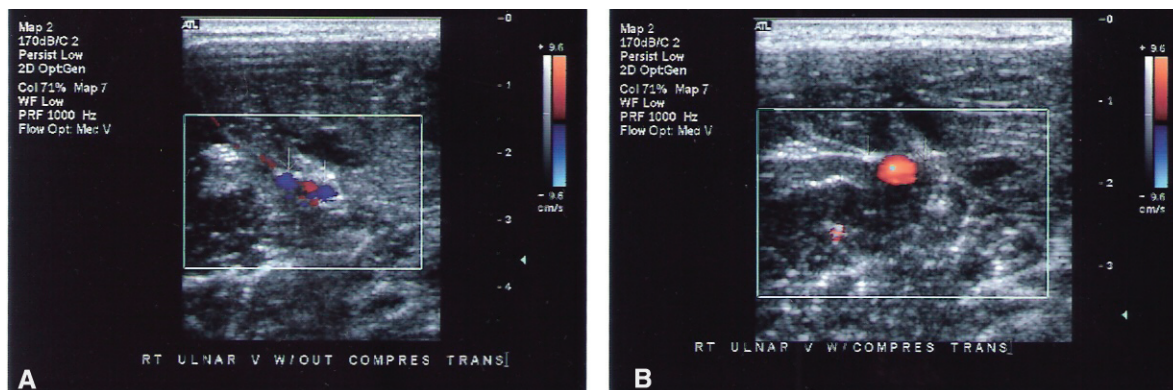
Repeat cross-sectional venous duplex ultrasounds taken in same plane 2 days later showed resolution of thrombus. (A) Red and blue flow indicates patent arterial and venous lumens in absence of compression. (B) Venous lumen obstructed by compression with ultrasound probe head.
